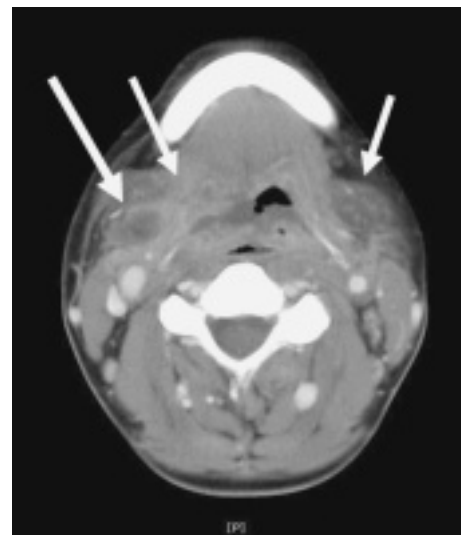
CT scan of neck on day 10. Abscess was shown.
